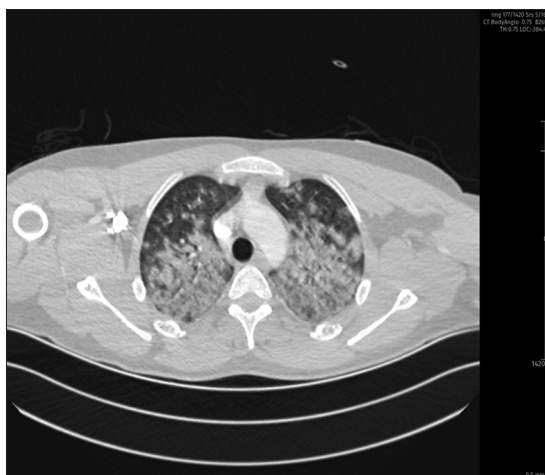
Patient's thorax computed tomography image (axial section)
